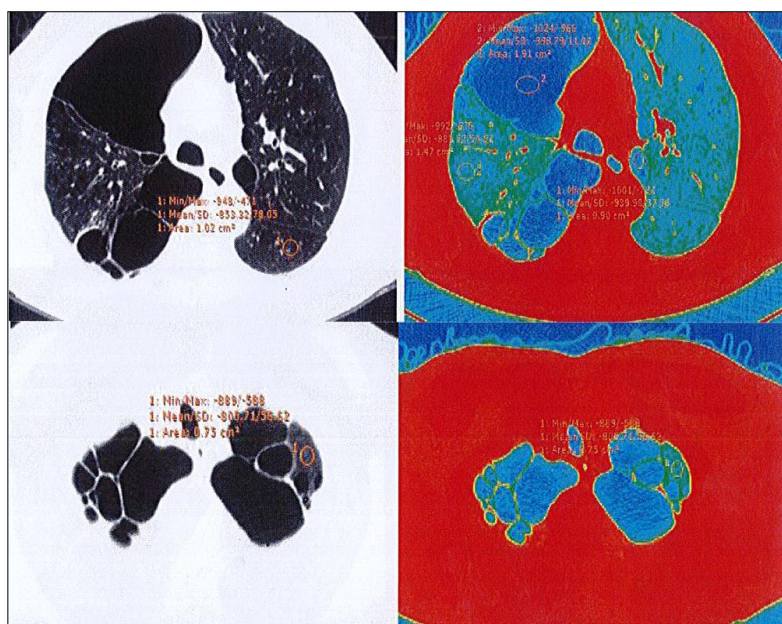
CT done showing mild to moderate bilateral emphysematous changes.
